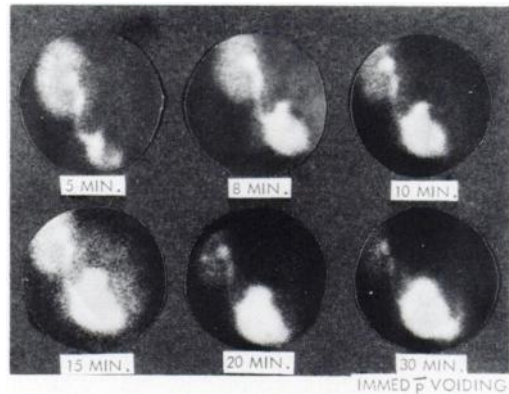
Renal transplant scintigraphic study of kidney, ureter, and bladder using ^{99m}Tc-Sn-DTPA shows progressive leakage around distal ureter.
